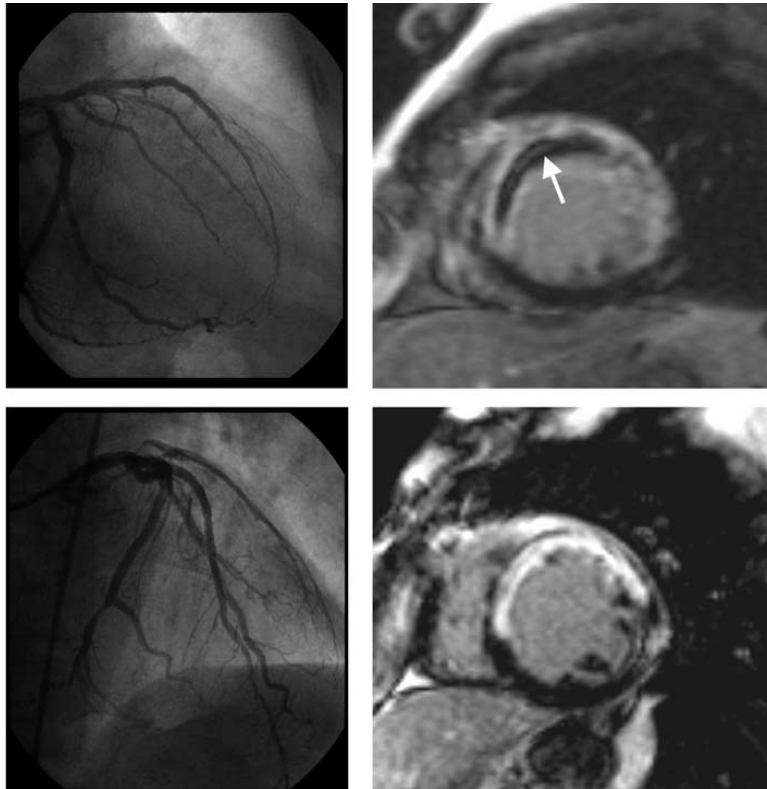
Coronary angiography and late gadolinium enhancement cardiovascular magnetic resonance imaging of two patients with an anterior myocardial infarction. After primary percutaneous intervention, TIMI flow grade 3 was established in the left anterior descending artery (left upper and lower panel). In one patient, on cardiovascular magnetic resonance imaging (right upper panel), late enhancement sequences show a large area of transmurular necrosis along the anterosseptal wall with a lack of contrast arrival in the core of the infarcted area (arrow). While infarct size was comparable, no evidence of microvascular obstruction was present in the other patient (right lower panel).
